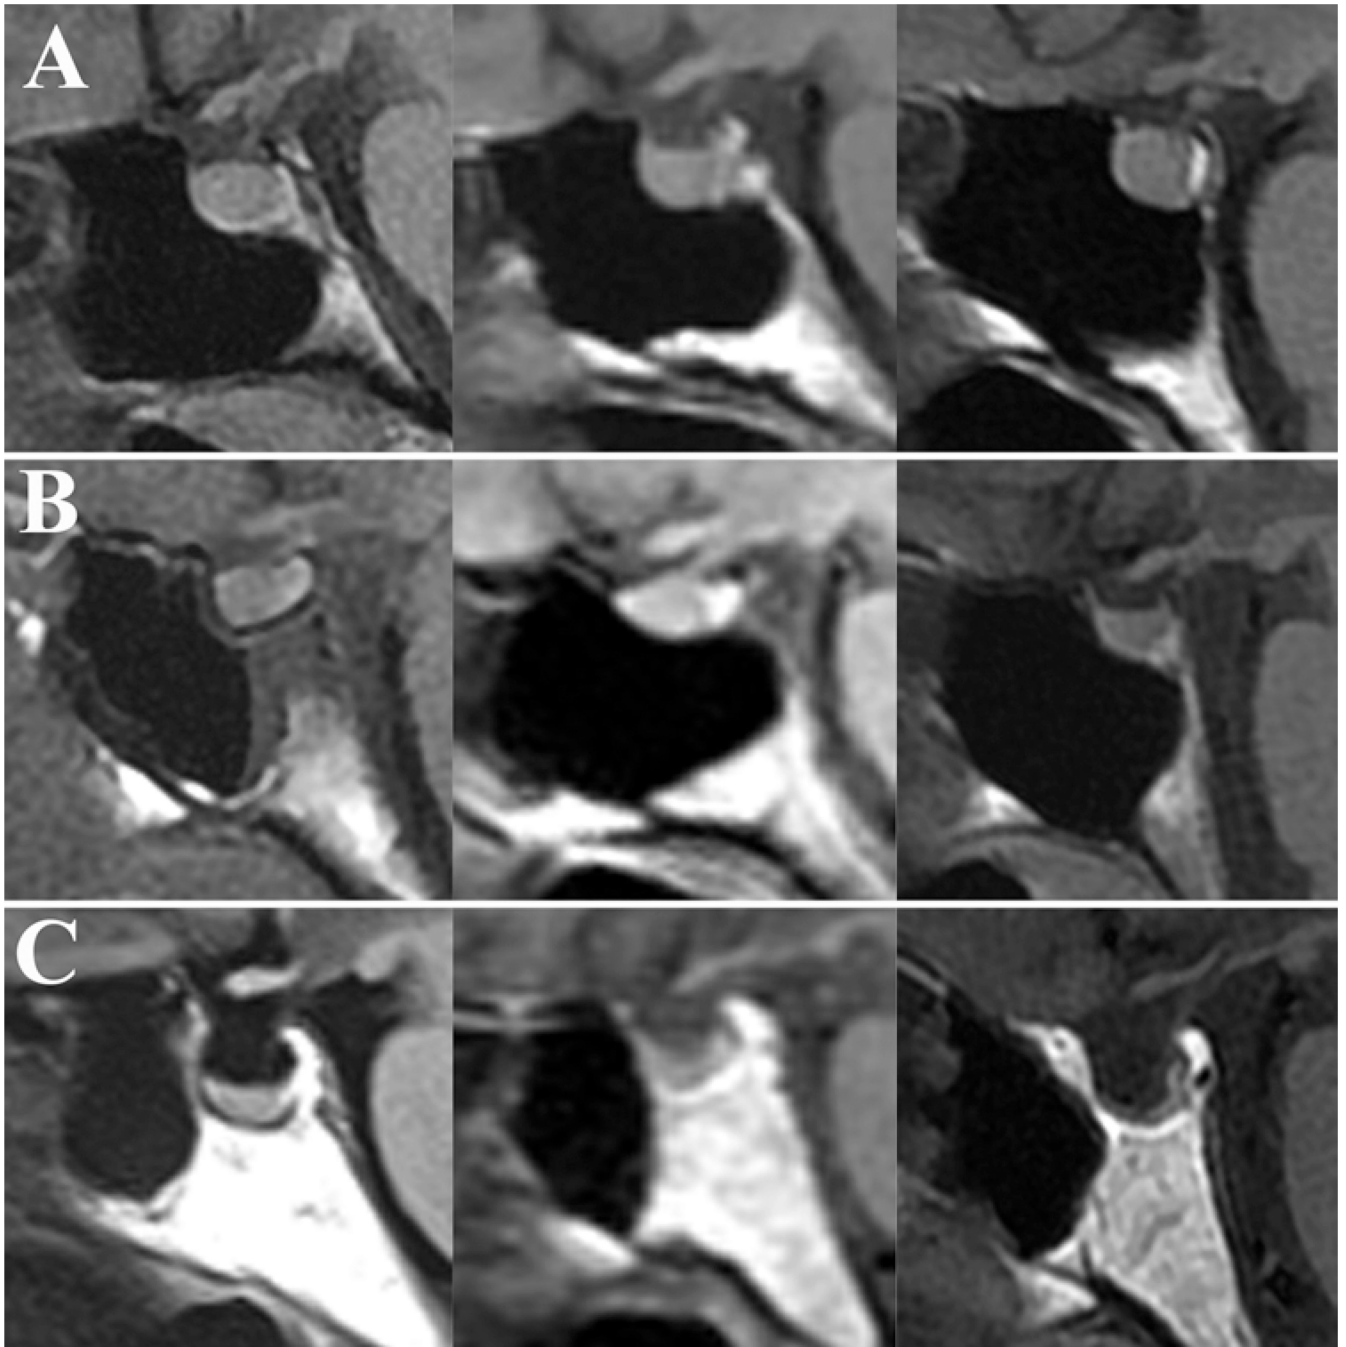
Sagittal MR images demonstrating the wide variability of sellar floor morphology in healthy adults. A: Representative example of the “prominent” sellar type (sellar angle $< 90^\circ$) identified in 25% of individuals. B: Example of the intermediate “curved” sellar type (sellar angle 90° – 150°) identified in 63% of individuals. C: Example of the less conspicuous “flat” sellar type (sellar angle $> 150^\circ$) identified in 11% of individuals and often associated with a presellar sphenoid sinus.
